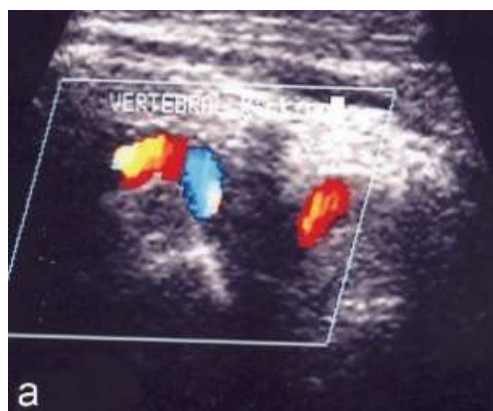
Vertebral artery S shaped elongation. A) Color Doppler mode. Longitudinal plane. b) MR angiography Gad-fl-2D-tof-MIP.
